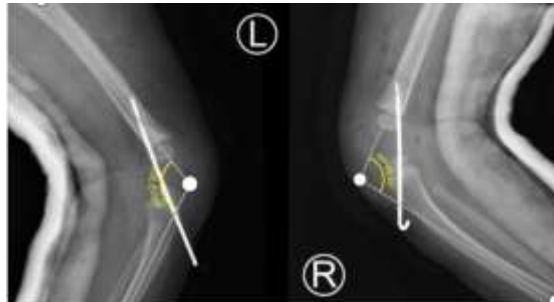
postoperative radiographic Images of the left and right knees after achieving 115° and 98° of knee flexion, in the left and right side respectively, the reduction was maintained with K-wire and the limbs were splinted in flexion.
